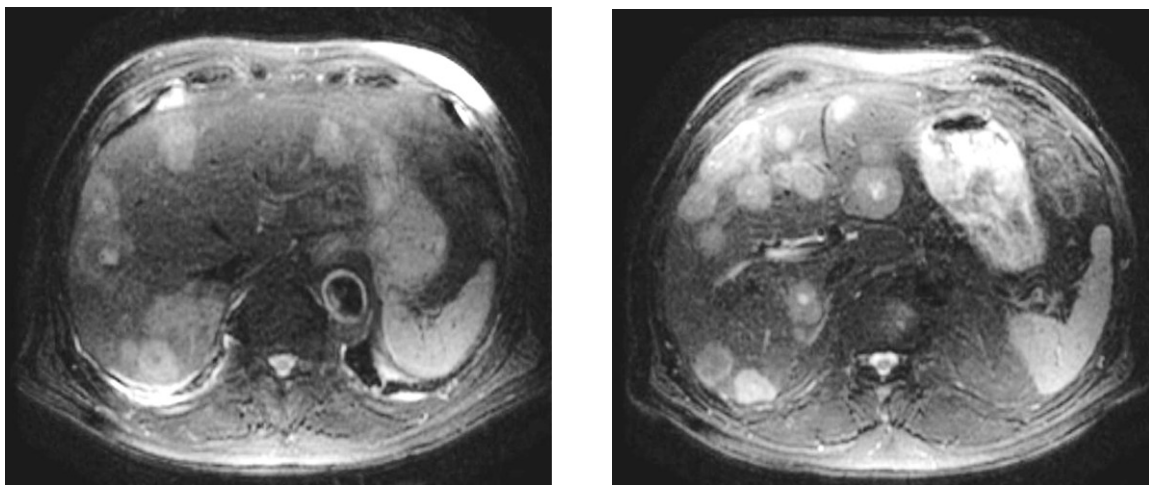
MRI showing multiple liver metastasis from prostatic cancer showing bull's eye appearance
